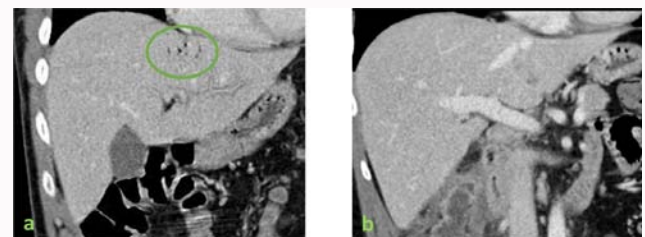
CT-Scan at admission (A) and at 15-days follow-up (B), showing complete resolution of the pneumobilia (circle) after appendectomy.
